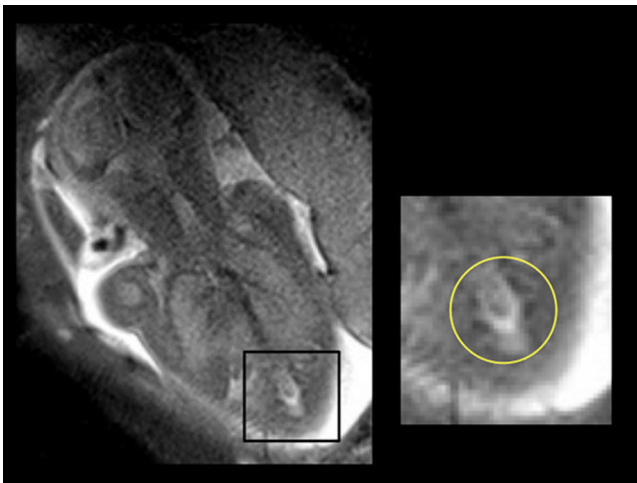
Box inset of fetal MRI is magnified to demonstrate blunted terminus of conus medullaris.
